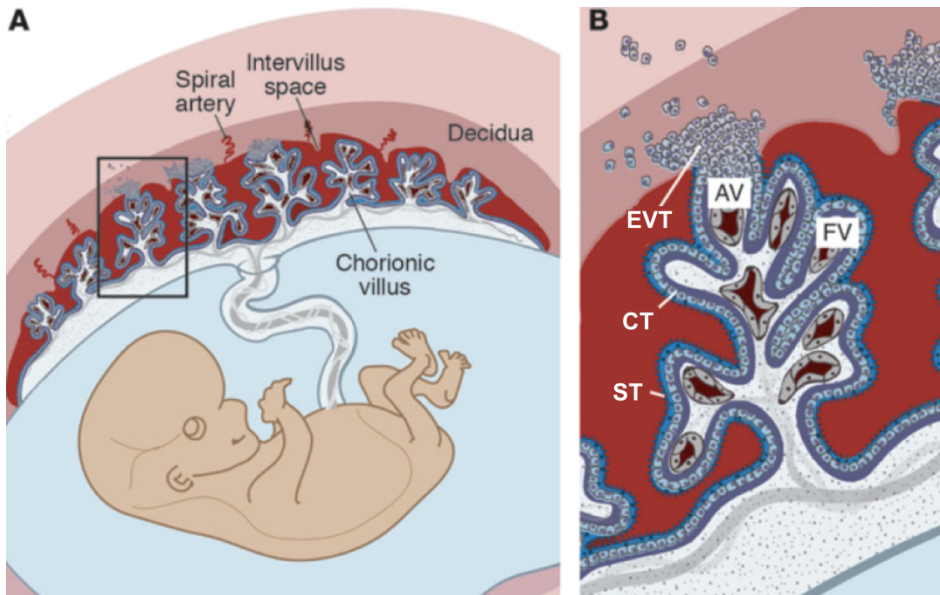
Anatomy of human placenta. A. Intervillous space between the chorion and the decidua is packed with chorionic villi and filled with maternal blood. B. The floating villi (FV) of placenta are covered with a continuous double-layer of trophoblast cells. The outer layer of multinuclear syncytiotrophoblast (ST) is in direct contact with maternal blood. The inner layer of mononuclear cytotrophoblast (CT) represents the progenitor population of trophoblast cells. Anchoring villi (AV) are attached to the uterus by invasive extravillous trophoblasts (EVT) (Maltepe *et al.*, 2010).
